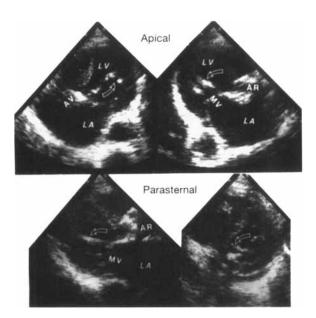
Two-dimensional echocardiogram in apical 4-chamber view (top left), apical long-axis view (top right), parasternal long-axis view (bottom left), and parasternal short-axis view (bottom right). Arrows indicate papillary muscle calcification; two "heads" of the posteromedial papillary muscle are calcified. LV = left ventricle, LA = left atrium, AV = aortic valve, AR = aortic root, MV = mitral valve.
